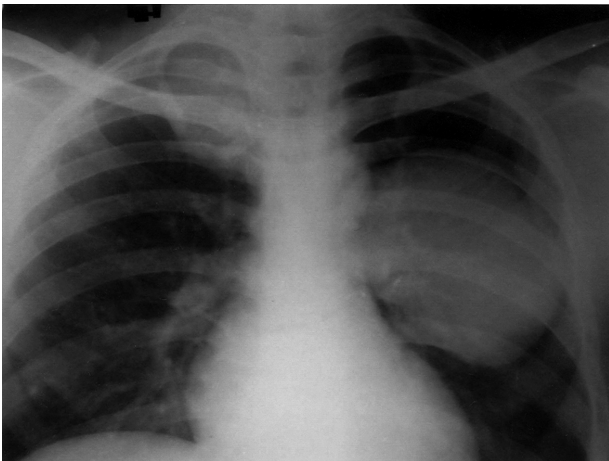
Chest radiograph (postero-anterior view) showing two homogeneous rounded opacities sharply circumscribed in the right upper and left mid zones.
